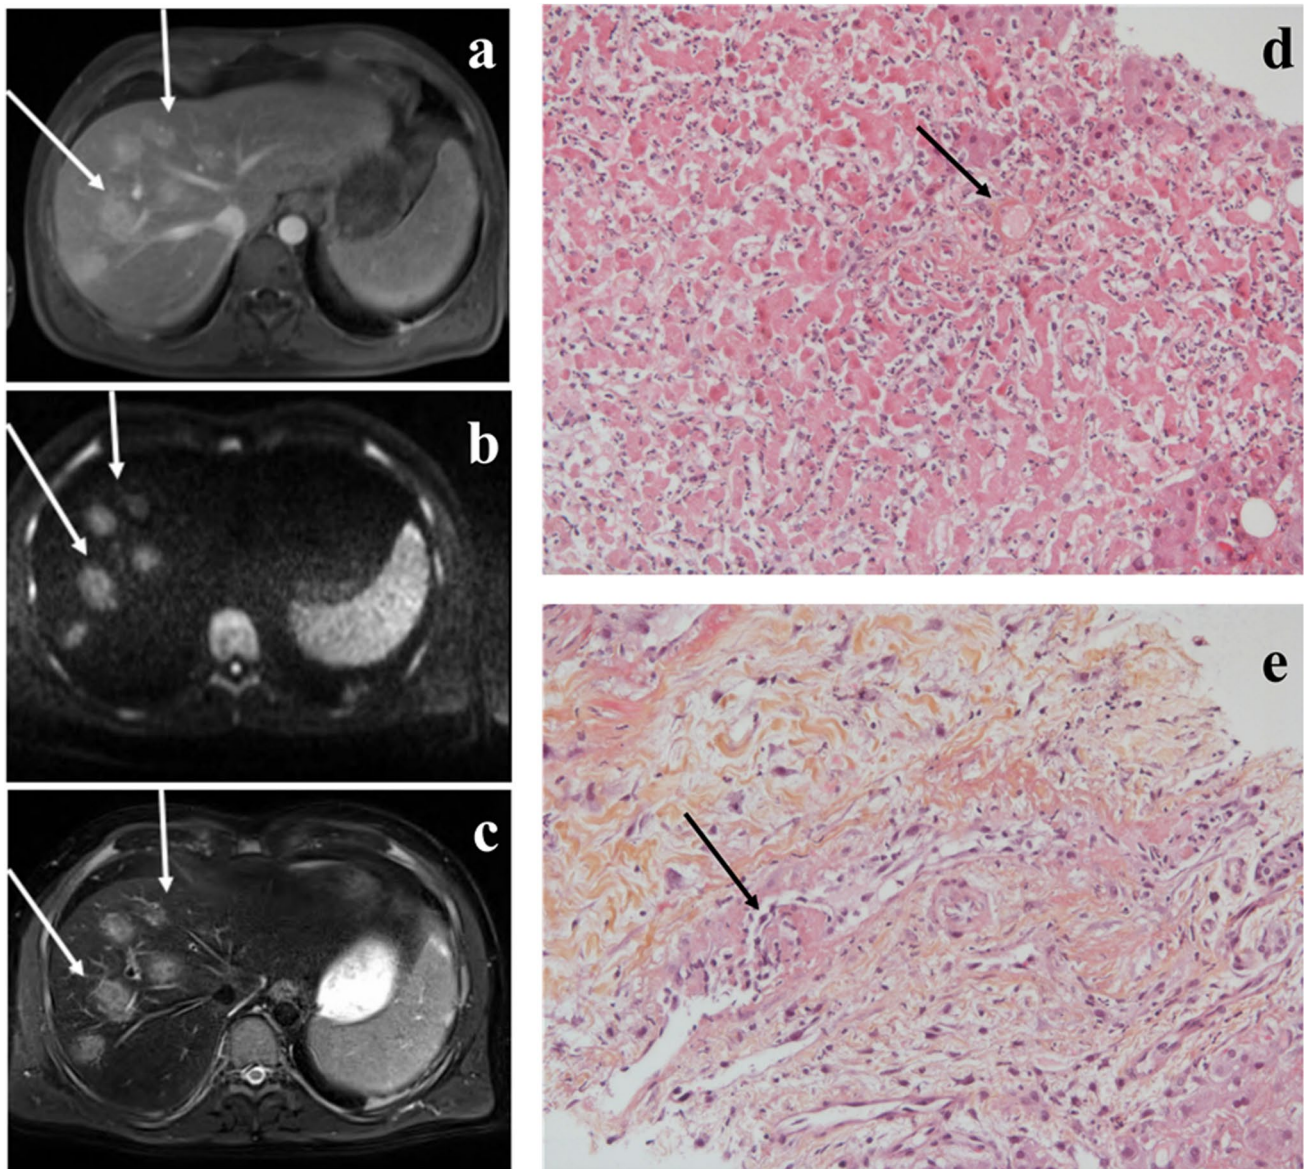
Hepatobiliary MRI showing multiple nodular lesions (arrows). a Axial T1 sat fat sequence showing enhancement of nodular lesions after contrast injection. b Axial DWI sequence showing hypersignal of nodular lesions. c Axial T2 showing hypersignal of nodular lesions. Targeted liver biopsy. d Infiltration of the hepatic lobular
